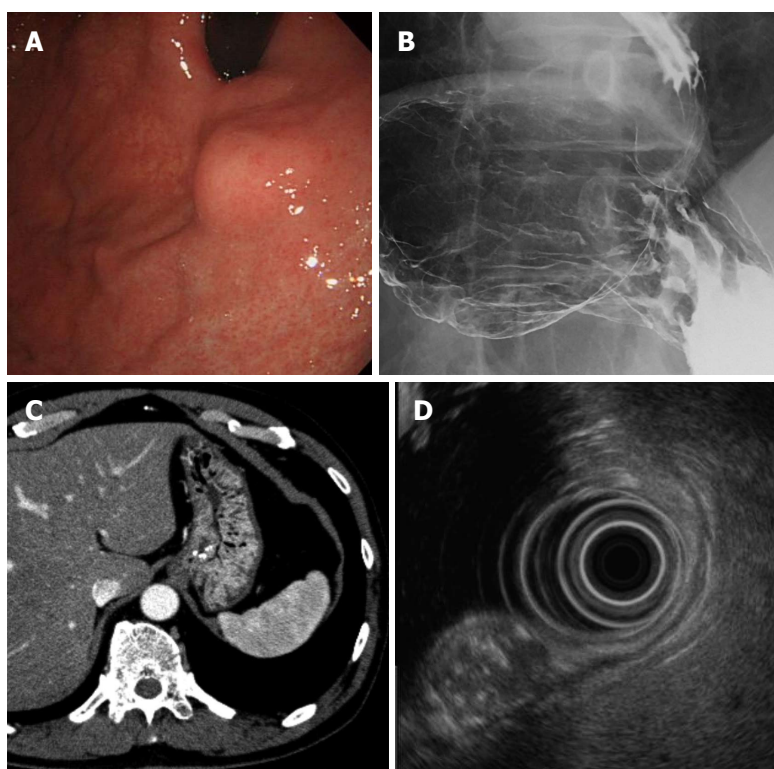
Results of pre-operative examinations. A: Endoscopic findings showing a submucosal lesion of 15 mm in diameter on the anterior wall of the upper gastric body near the esophago-gastric junction. The surface was covered with normal gastric mucosa; B: Barium gastrography showed a smooth elevated lesion of 2 cm in diameter on the anterior wall of the upper gastric body near the esophago-gastric junction; C: Computed tomography revealed a 15-mm submucosal low density area with calcification in the anterior wall of the upper gastric body. No lymph node or distant metastasis was detected; D: Endoscopic ultrasound showed an 11.2 mm × 13.5 mm submucosal tumor derived from the third layer of the gastric wall as a heterogeneous lesion with a mixture of a high echoic lesion, low echoic lesion, and calcification.
